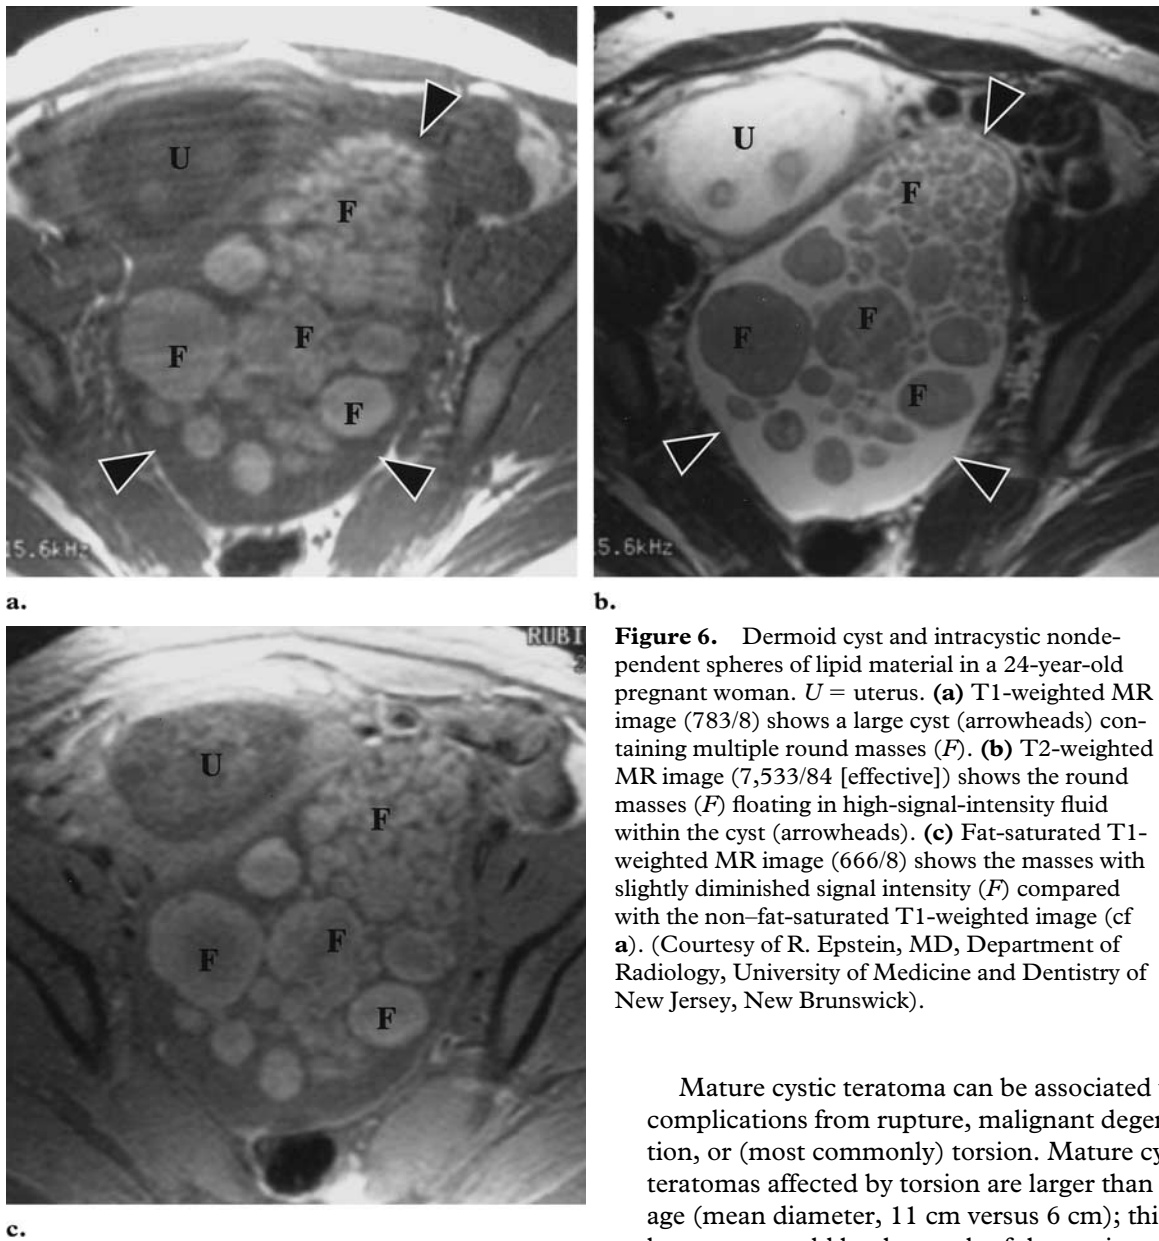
Dermoid cyst and intracystic nondependent spheres of lipid material in a 24-year-old pregnant woman. *U* = uterus. (a) T1-weighted MR image (783/8) shows a large cyst (arrowheads) containing multiple round masses (*F*). (b) T2-weighted MR image (7,533/84 [effective]) shows the round masses (*F*) floating in high-signal-intensity fluid within the cyst (arrowheads). (c) Fat-saturated T1-weighted MR image (666/8) shows the masses with slightly diminished signal intensity (*F*) compared with the non-fat-saturated T1-weighted image (cf a). (Courtesy of R. Epstein, MD, Department of Radiology, University of Medicine and Dentistry of New Jersey, New Brunswick).
